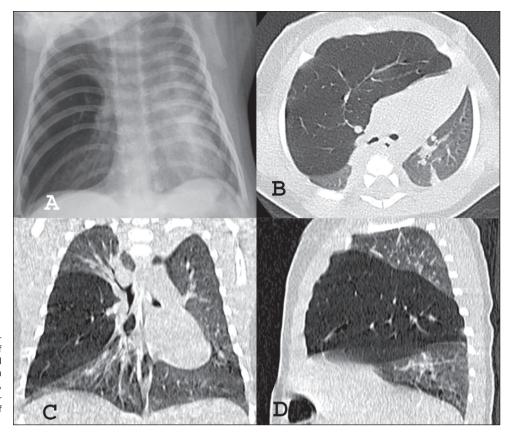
Chest X-ray in anteroposterior view (A) showing hyperlucency of the right hemithorax with a mediastinal shift to the left. Noncontrast chest CT, in axial, coronal, and sagittal slices (B, C, and D, respectively), showing hyperinflation of the middle lobe and expansion of the mediastinal structures.
